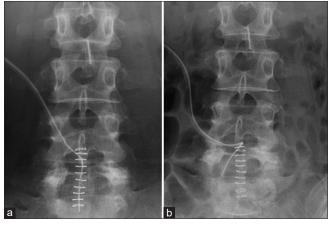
(a and b) The comparative X-ray between postoperative day 0 and day 1. (a) Postoperative X-ray image at day 0. Drain was correctly placed dorsal to the S1 lamina. (b) Postoperative X-ray image at day 1. Drain was migrated into the right L5S1 lateral recess.
